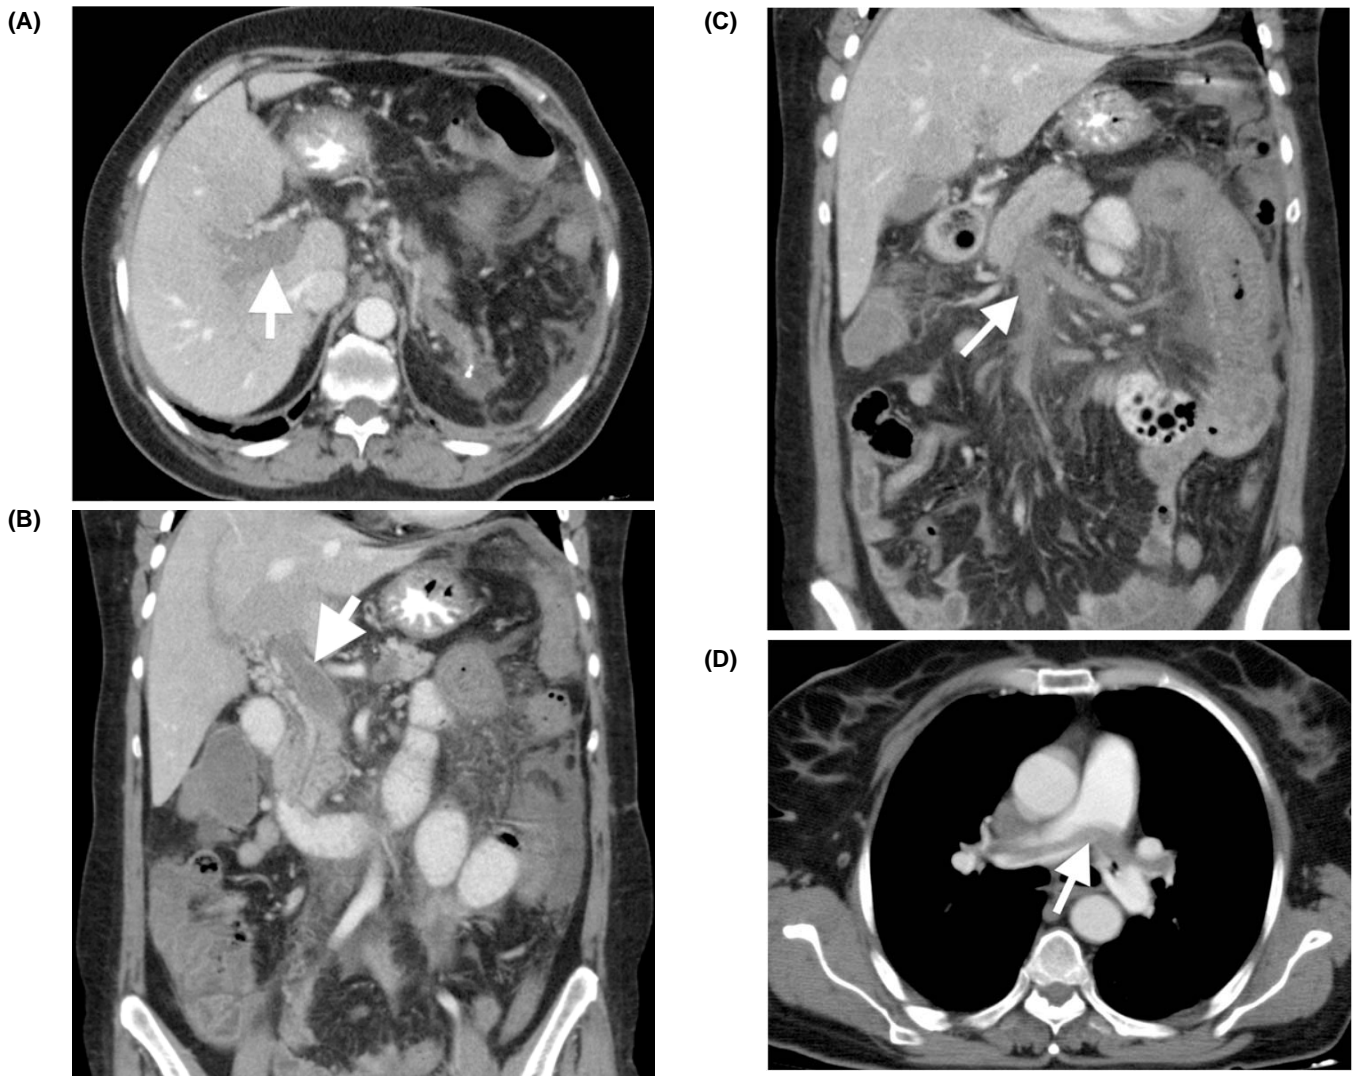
Thrombosis of portal vein and pulmonary artery. Axial (A) and coronal (B) contrast enhanced CT images demonstrate hypodense filling defects (arrows) in portal veins consistent with portal vein thrombosis. (C) Coronal contrast enhanced CT reveals thrombosis of superior mesenteric vein (arrow). (D) Axial contrast enhanced CT reveals hypodense filling defect (arrow) resulting in partial thrombus of pulmonary artery.
